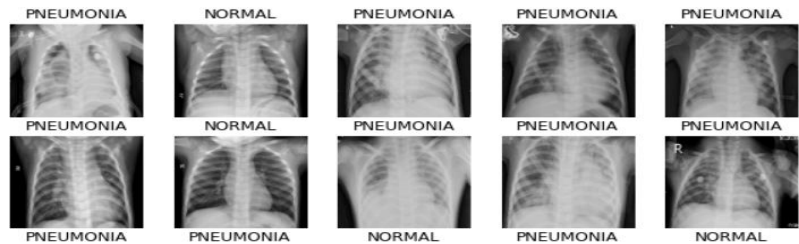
Examples of X-ray images classified as pneumonia and normal
